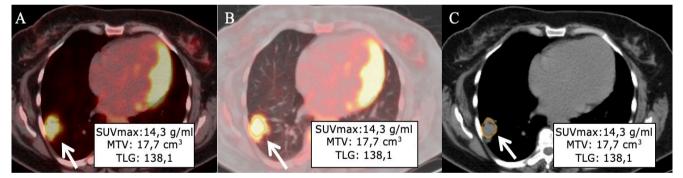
Pretreatment ¹⁸F-FDG PET/CT images of a patient with NSCLC and EGFR mutation, demonstration of SUVmax, MTV, and TLG values derived from the primary lung tumor (arrow) on axial fused images (a,b) and axial CT images (c)
